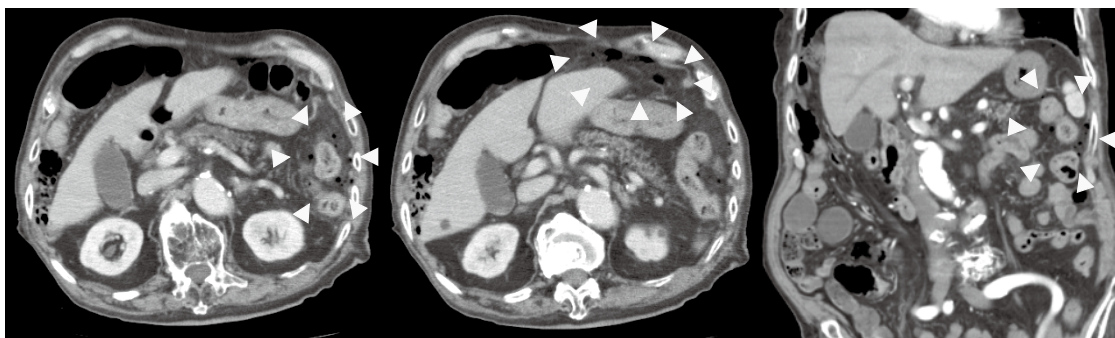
Computed tomography showing free air in the left side of the abdomen, with no obvious ascites in the surrounding area.
